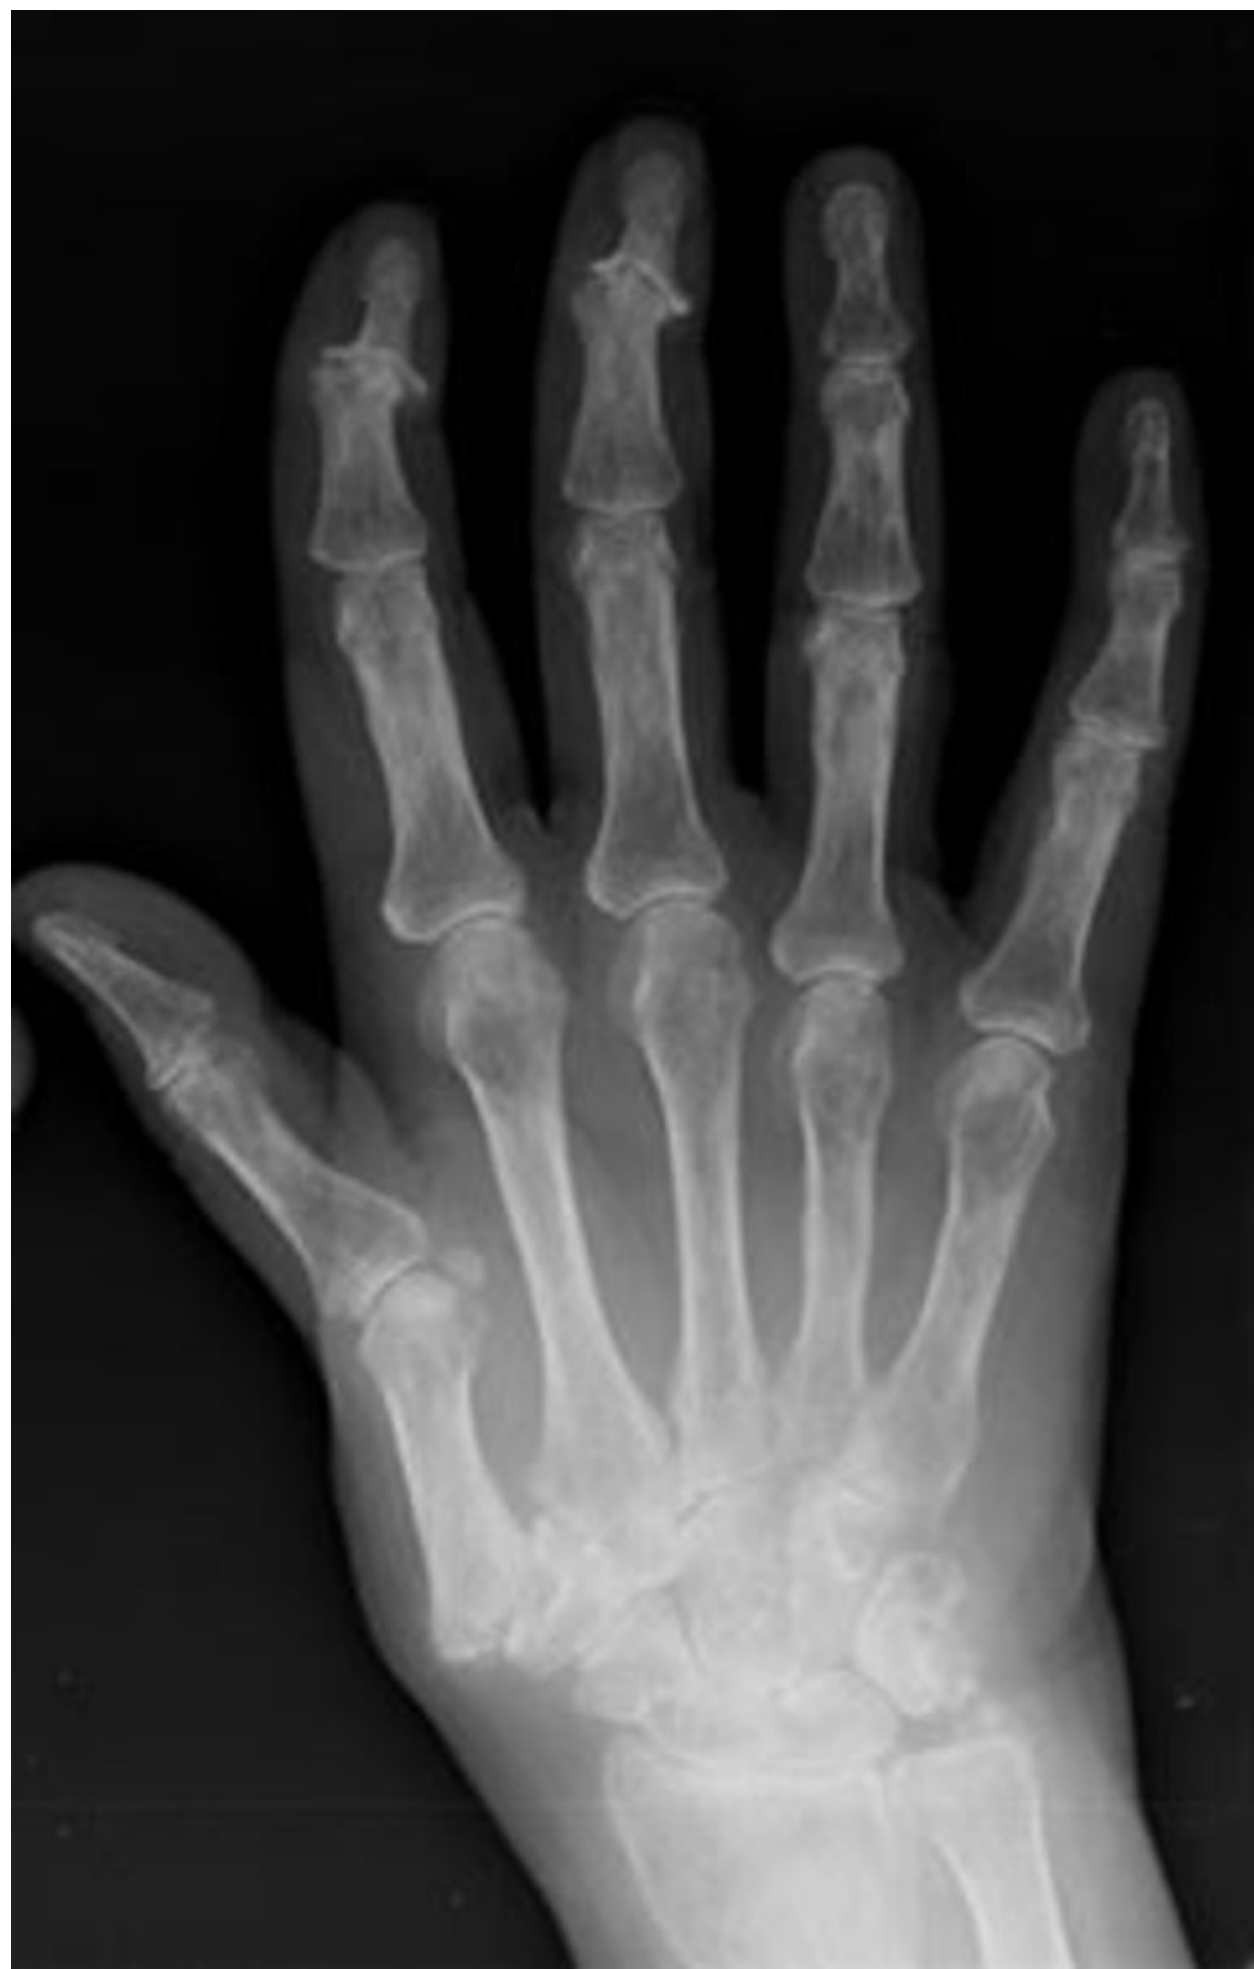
Erosive osteoarthritis. PA radiographic view with changes in DIP and PIP joints.
